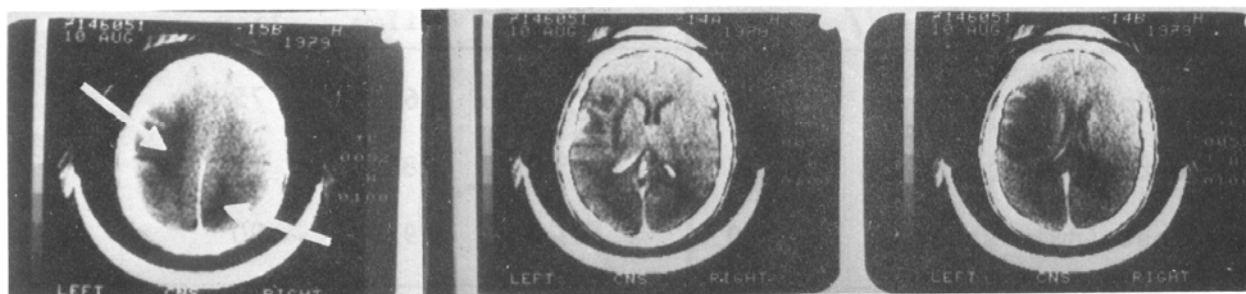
CT scan showing a contrast enhancing lesion with surrounding edema in the left parietal area and a non-enhancing lesion, mostly edema, in the right occipital area.
